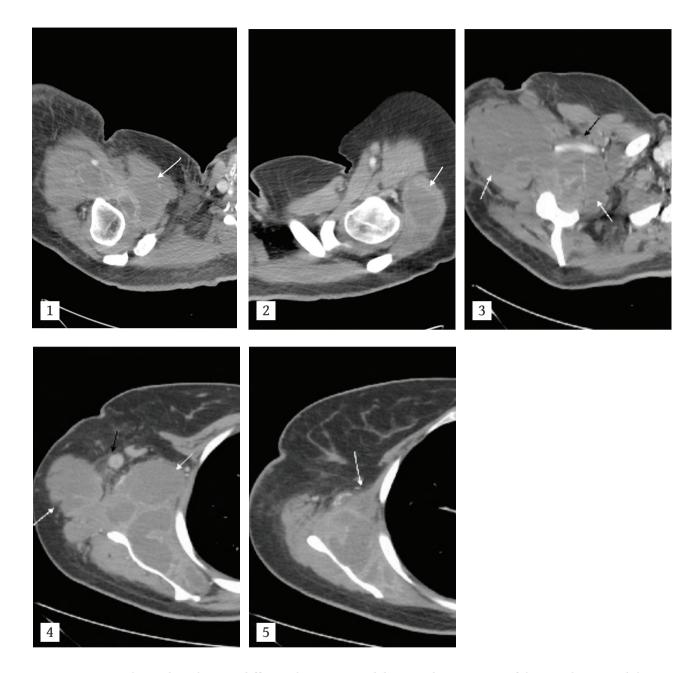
Contrast enhanced CT showing diffuse enlargement and decreased attenuation of the muscles around the right shoulder and arm (pectoralis minor, deltoid and biceps) with peripherally enhancing intramuscular fluid collections consistent with abscesses (arrow). Findings in keeping with multifocal pyomyositis. Swelling of the right arm and subcutaneous edema-inflammatory changes are also noted
